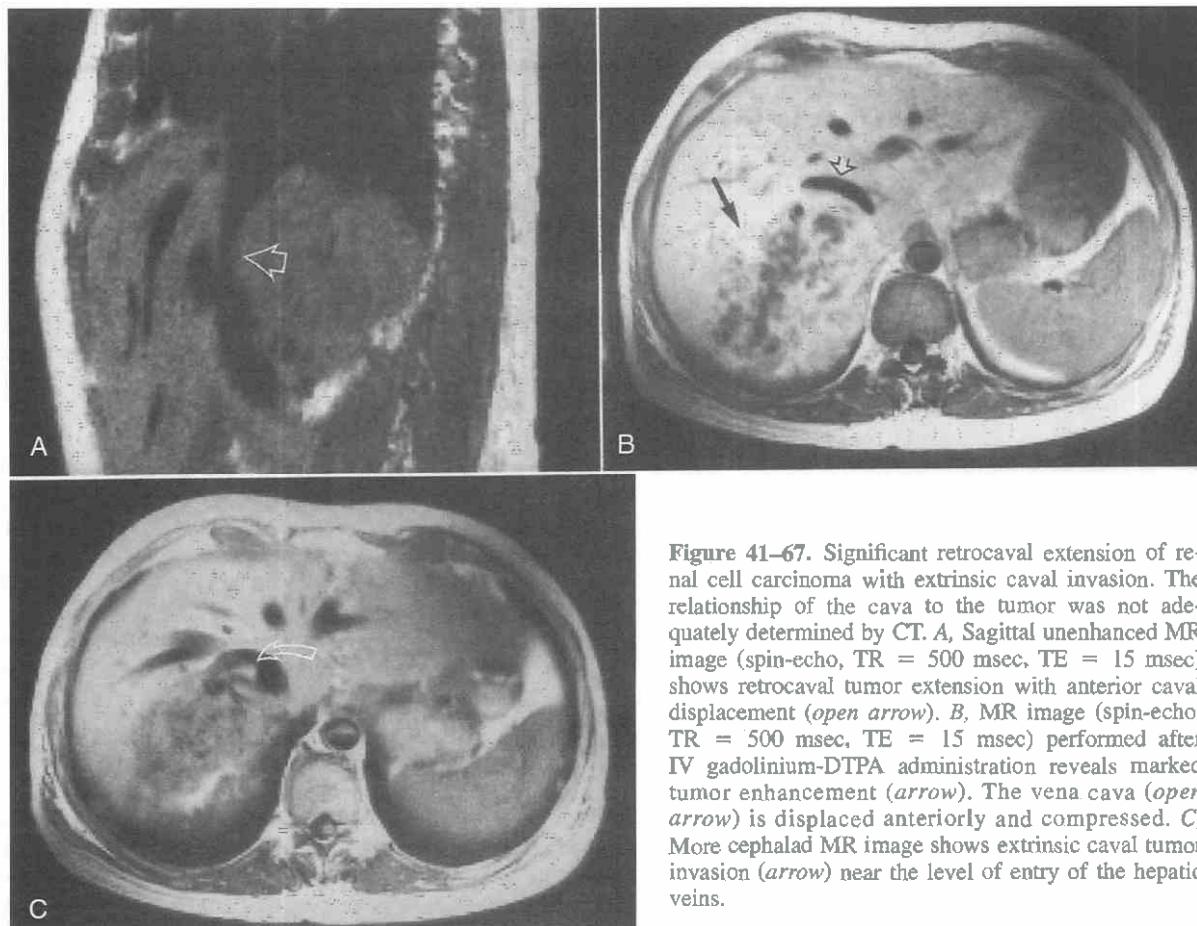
Significant retrocaval extension of renal cell carcinoma with extrinsic caval invasion. The relationship of the cava to the tumor was not adequately determined by CT. A, Sagittal unenhanced MR image (spin-echo, TR = 500 msec, TE = 15 msec) shows retrocaval tumor extension with anterior caval displacement (*open arrow*). B, MR image (spin-echo, TR = 500 msec, TE = 15 msec) performed after IV gadolinium-DTPA administration reveals marked tumor enhancement (*arrow*). The vena cava (*open arrow*) is displaced anteriorly and compressed. C, More cephalad MR image shows extrinsic caval tumor invasion (*arrow*) near the level of entry of the hepatic veins.
